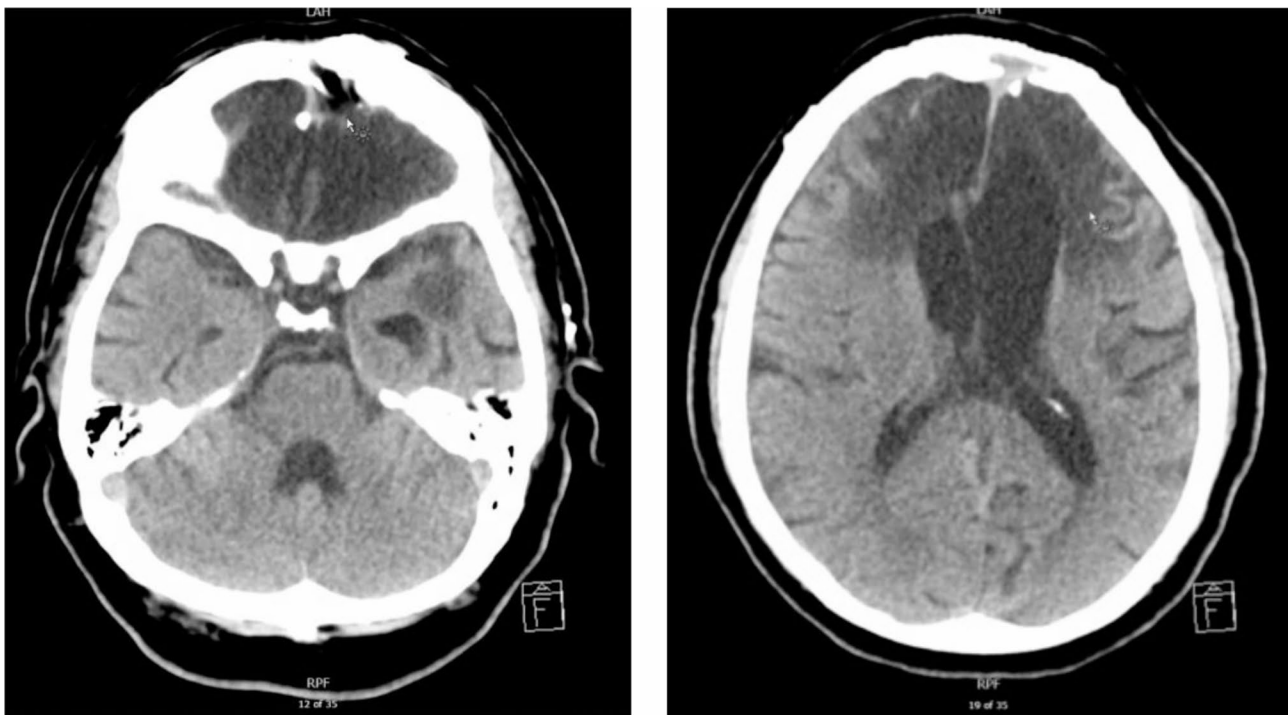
Non-contrasted CT scan of the brain obtained 7 years after injury reveals encephalomalacia of the bilateral frontal and left temporal lobes
